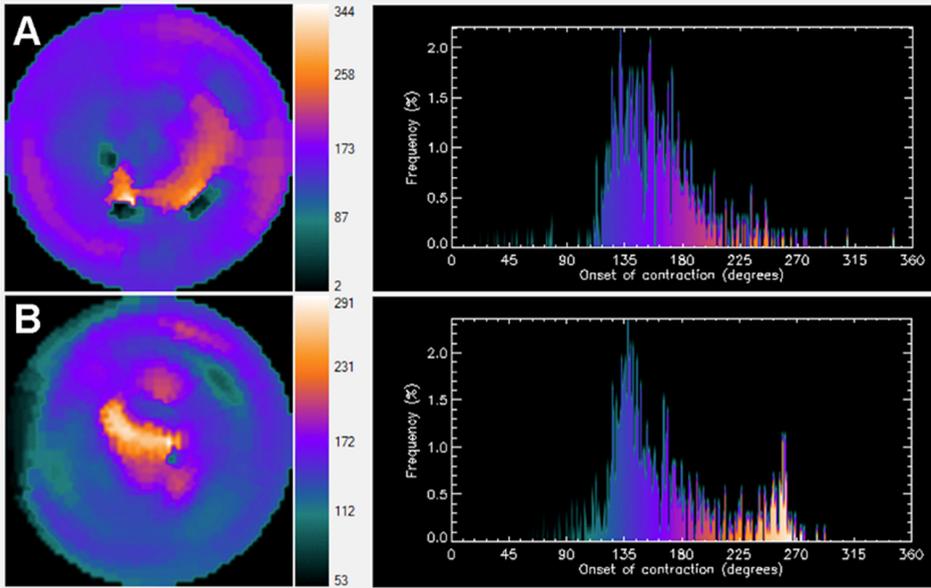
Area of latest mechanical activation as assessed with phase analysis on gated myocardial perfusion single photon emission computed tomography (SPECT) (GMPS).
